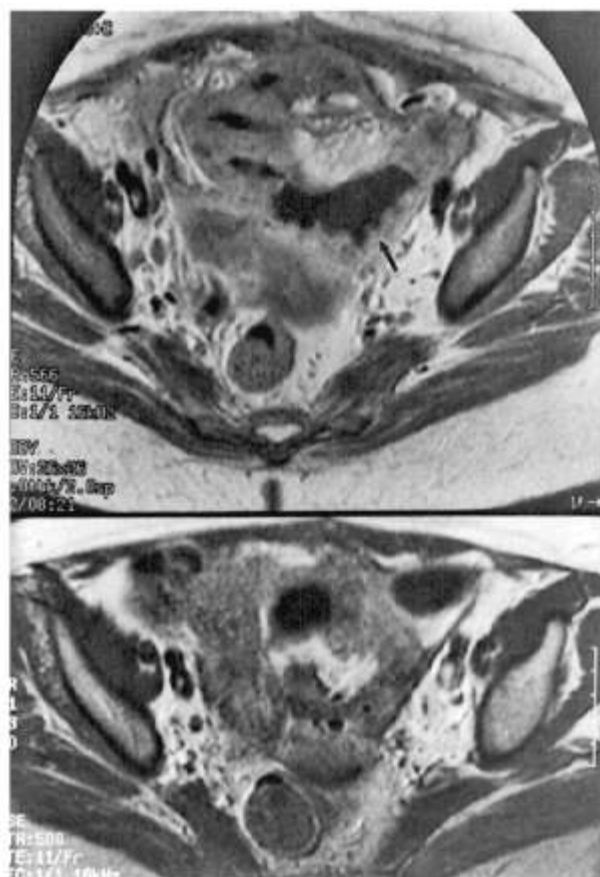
(Top) Intravenous contrast enhanced T1-weighted pelvic MR scan on 14 July 1994 reveals extensive pelvic disease involving multiple bowel loops with foci of necrosis identified (arrow). (Bottom) Follow-up MR scan on 15 December 1994 reveals marked resolution of disease.
